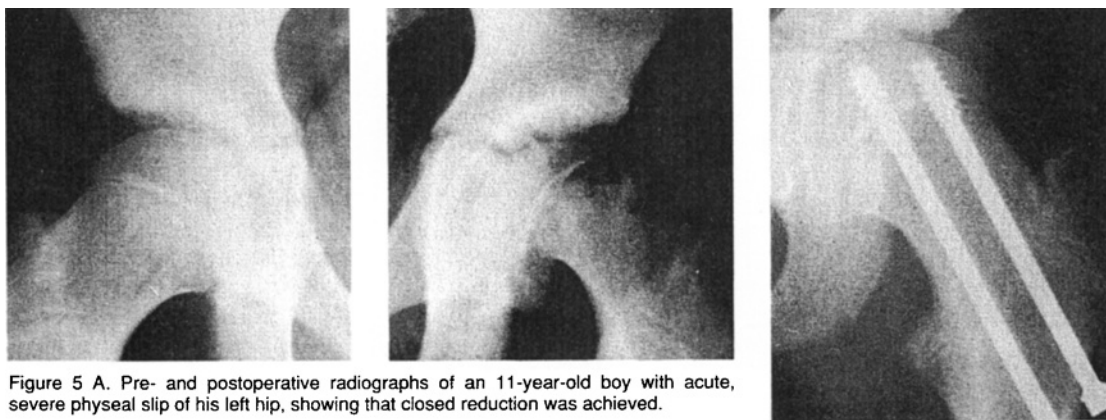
A. Pre- and postoperative radiographs of an 11-year-old boy with acute, severe physeal slip of his left hip, showing that closed reduction was achieved.
